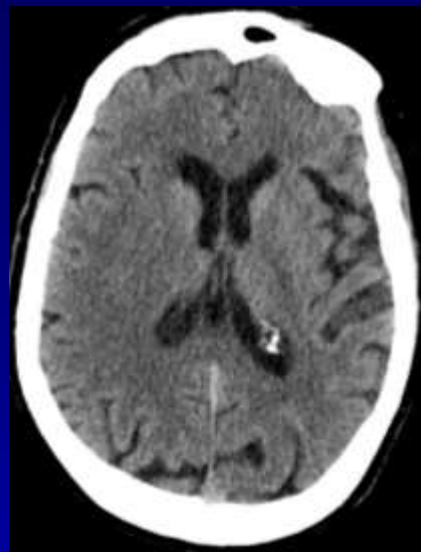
ASPECTS and functional outcome
